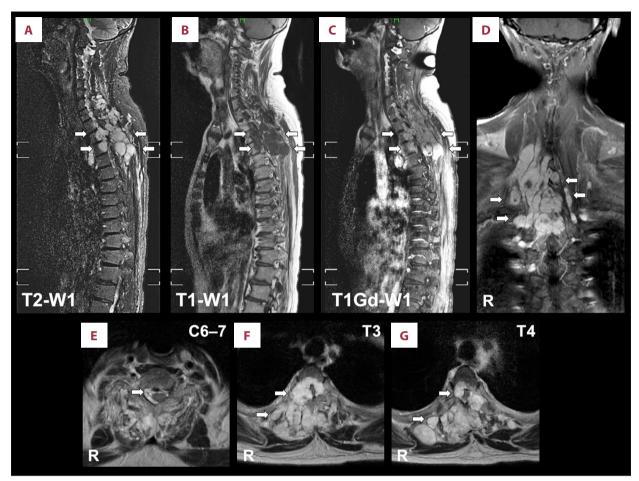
Preoperative magnetic resonance images (MRI) of the spine showing multiple mass lesion at C7-T5 level. (A, B) Sagittal T2-weighted (A) and T1-weighted (B) images showing multiple high-intensity mass lesion at C7-T5 level. (C) A sagittal gadolinium-enhanced T1-weighted image showing multiple enhanced mass lesion at C7-T5 level. (D) Coronal T2-weighted image showing multiple high-intensity mass lesion. (E) An axial T2-weighted image showing an extradural high-intensity mass lesion at the right side of C6/7. (F, G) Axial T2-weighted images showing multiple mass lesion at the T3 (F) and T4 (G) invading rib, vertebrae, and spinal canal with spinal cord compression. White arrows indicate the tumor.
